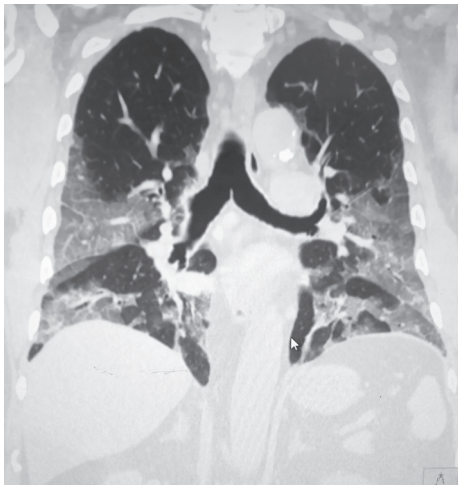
(Patient 2) HRCT chest (noncontrast)
